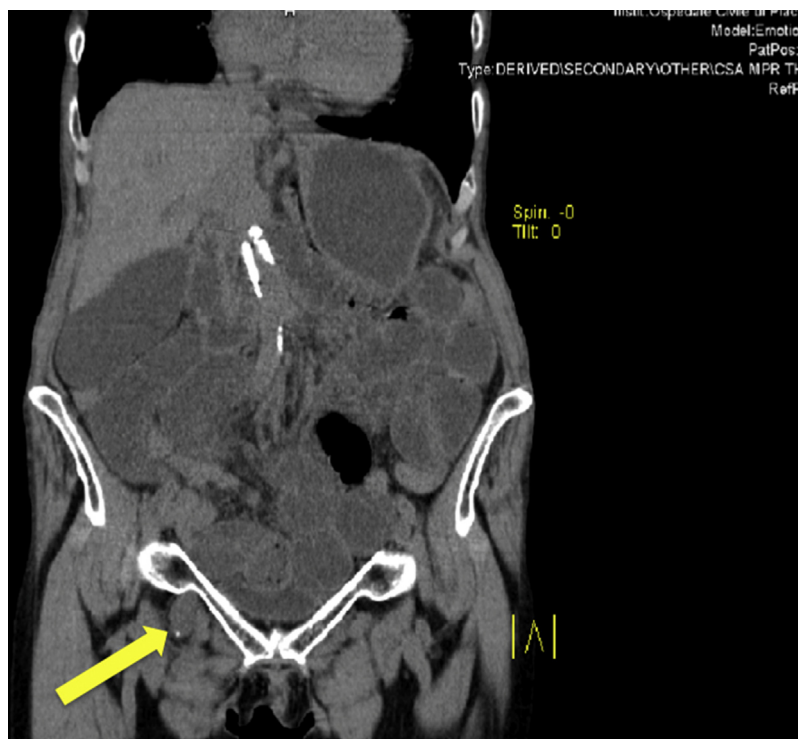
CT scan, sagittal section: right obturator hernia.
